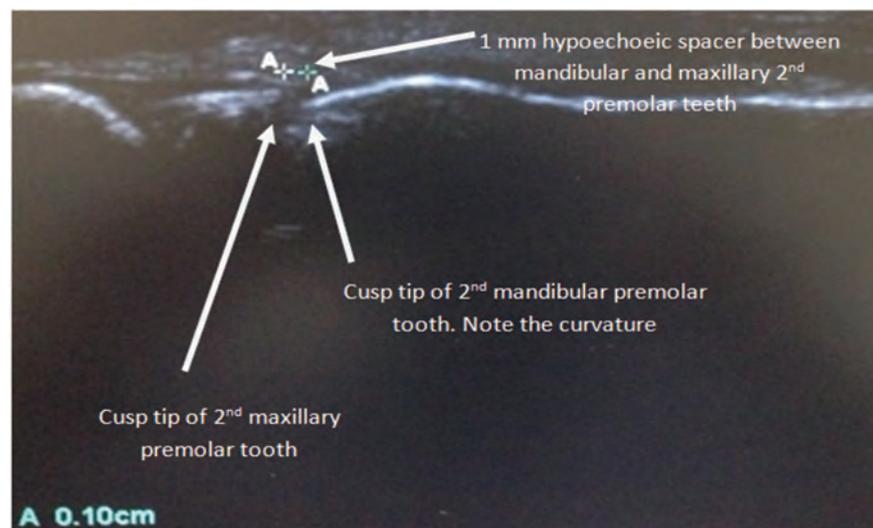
Ultrasound image showing cusp tips of the 2nd premolar teeth with interposing 1 mm hypoechoic spacer.
